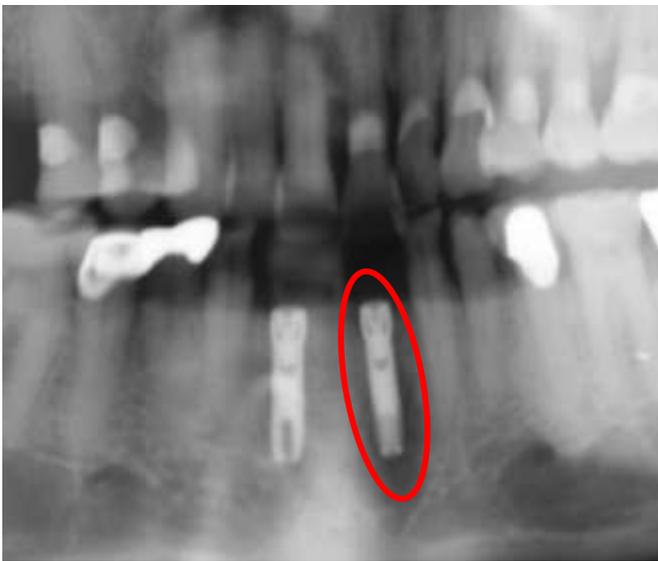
Implant at site of #23 shows periapical radiolucency
